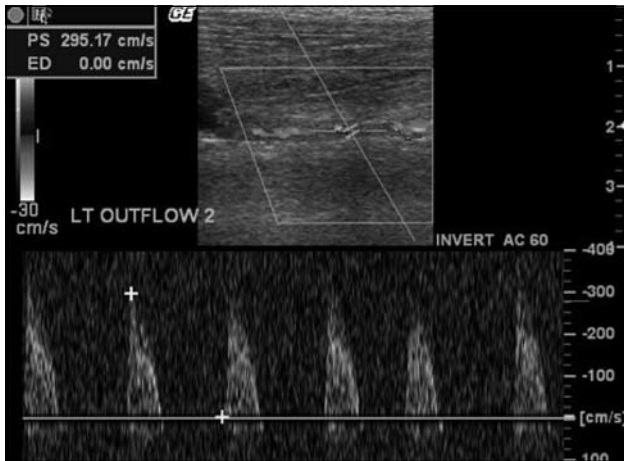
Peak systolic velocities are elevated (295 cm/sec) at the point of abnormal color Doppler signals. This indicates a focal stenosis of 50 to 75% in the native artery distal to the graft.
